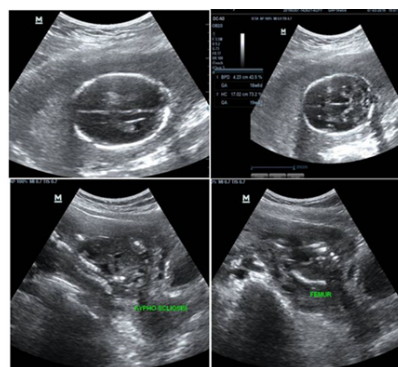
The Ultrasonography Images Showing Normal CNS Structure, Anhydramnios, Defect In Development Of Spine And Lower Pelvic Bone with a single femur.
